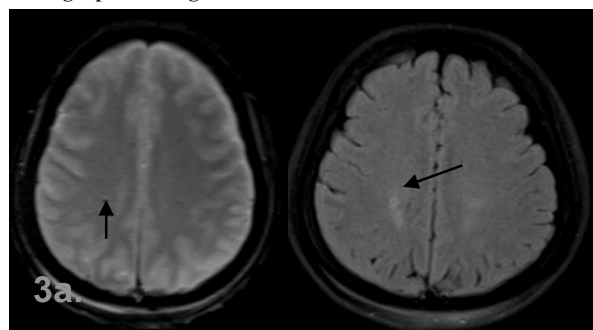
Axial brain images of above mentioned same patient 36 year old female with history of head trauma showing restriction on GRE (figure 3a) with perifocal hyperintense edema on T2 FLAIR sequence (figure 3b) in right centrum semiovale.
